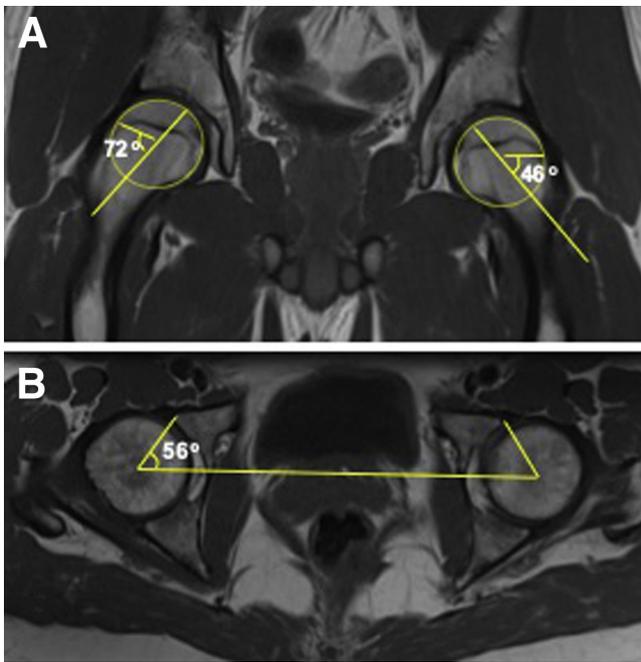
(A) Coronal magnetic resonance image of bilateral hips. The alpha angle (α) was measured as the angle between the line drawn through the centers of the femoral neck and head and the line drawn from the center of the femoral head to the anterior point, where the distance exceeds the radius of the femoral head. The pathologic alpha angle on the right should be noted. (B) An axial magnetic resonance image through the center of the femoral head is used for measurement of the anterior acetabular sector angle, that is, the angle between the inter-capital centerline and the line from the center point of the head to the anterior acetabular rim.
